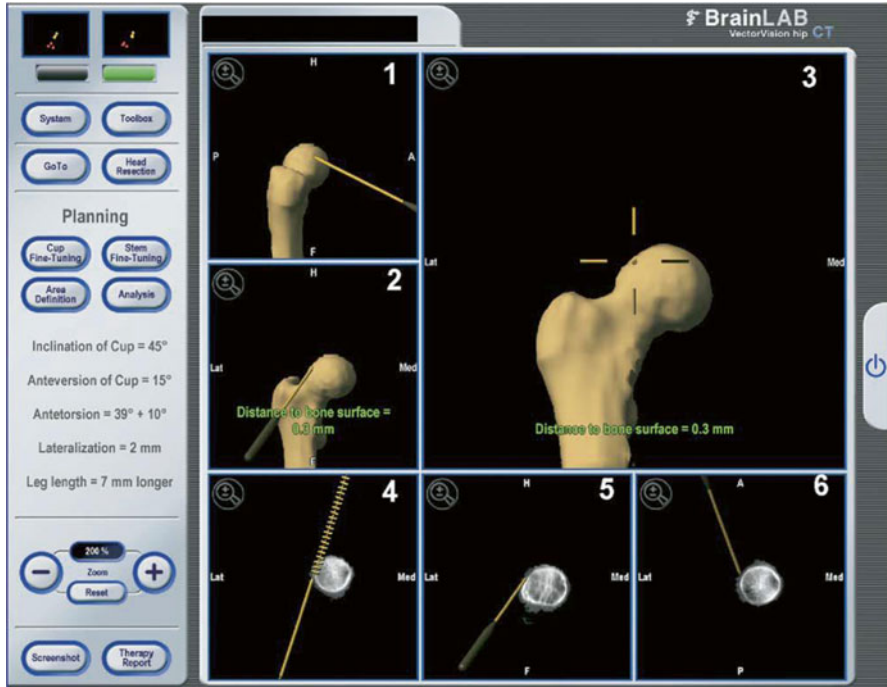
The screen shows the position of the surgical instrument in relation to the femoral neck (frame 1, lateral 3-dimensional view; frames 2 and 3, anteroposterior 3-dimensional views; frame 4, anteroposterior 2-dimensional view; frame 5, lateral 2-dimensional view; and frame 6, transversal 2-dimensional view). The scripture at the right part of the screen represents a residuum of the original Hip-CT program and is not used in navigated hip arthroscopy. Reproduced from Brunner et al. [30] with permission from Elsevier.
